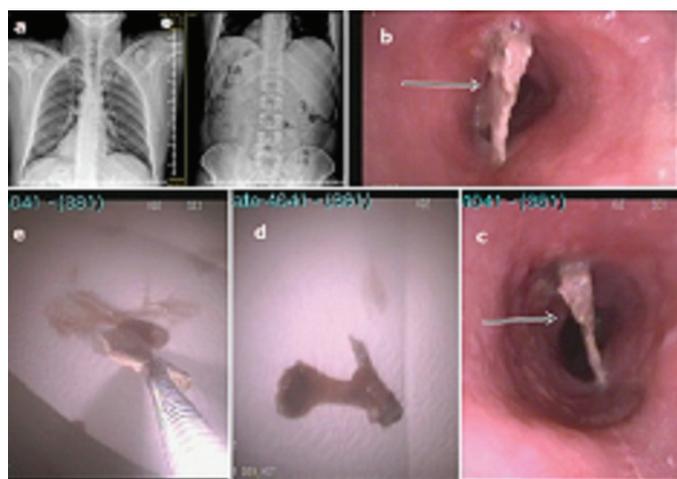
a. Plain radiographs; the swallowed bone piece is not selected because it is a superposition, b. Endoscopic view, c. and d. Removal of the bone piece by forceps
